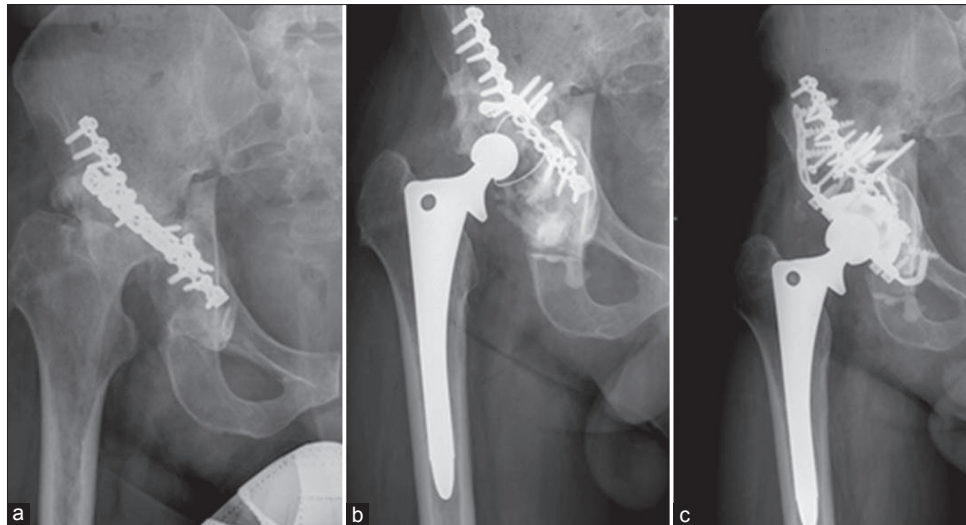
Preoperative X-ray of (R) hip joint showing (a) with infected acetabular implant *in situ* (b) failure of staged cemented acetabular implant with bone graft for defect (c) 2 years postoperative staged acetabular reconstruction with bone graft
